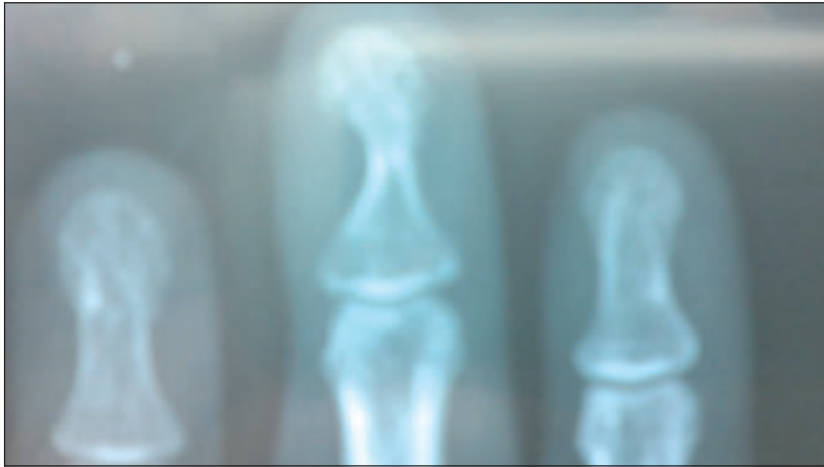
X-ray showing scalloping on the radial side of distal phalans of middle finger.
